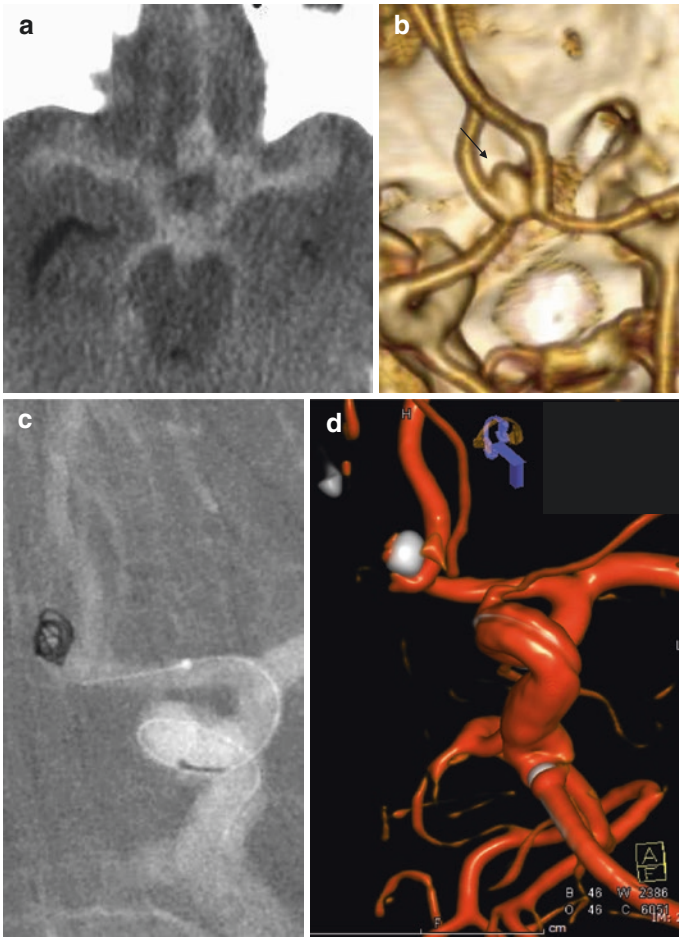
This 61-year-old woman presented with a sudden-onset, severe headache. (a) A CT head (axial) demonstrates a starburst pattern of subarachnoid hemorrhage. (b) A 3D reconstruction of a CTA demonstrates a small anterior communicating artery (AComA) aneurysm (*arrow*). (c) A road map of a diagnostic cerebral angiogram (left internal carotid artery (ICA) injection, oblique view) during endovascular coiling of the ruptured AComA aneurysm. (d) A 3D (dual volume) reconstruction of a spin angiogram (left ICA injection, oblique view) demonstrates complete exclusion of the ruptured AComA aneurysm
